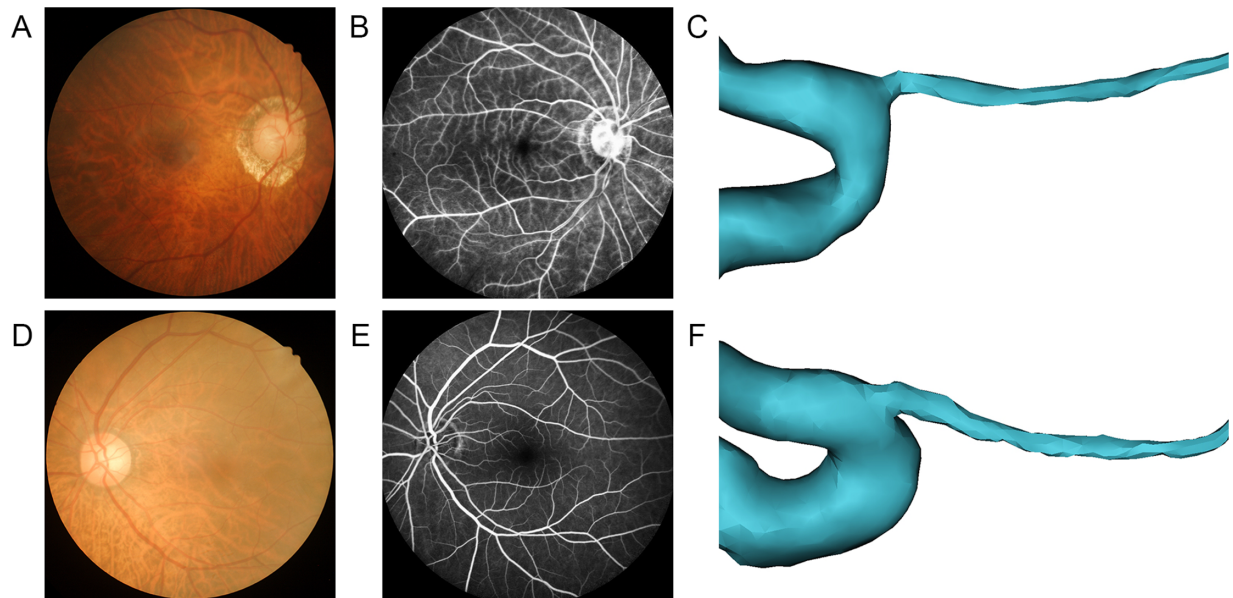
Characteristic fundus photographs, fundus fluorescein angiography (FFA) images, and the 3D models of the OA reconstructed by using CTA images in patients with OIS and controls. (A–C) Fundus photograph, FFA image, and 3D model of the OA in a 70-year-old male with OIS. (D–F) Fundus photograph, FFA image, and 3D model of the OA in a 69-year-old female control.
